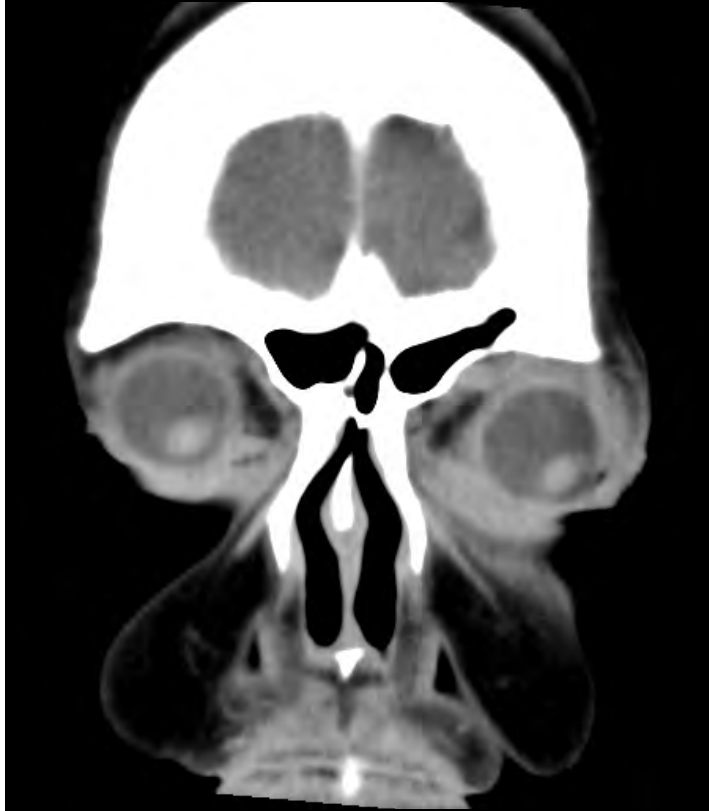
Maxillofacial CT without contrast demonstrating a diffuse mass in the superior aspect of the left orbit.
